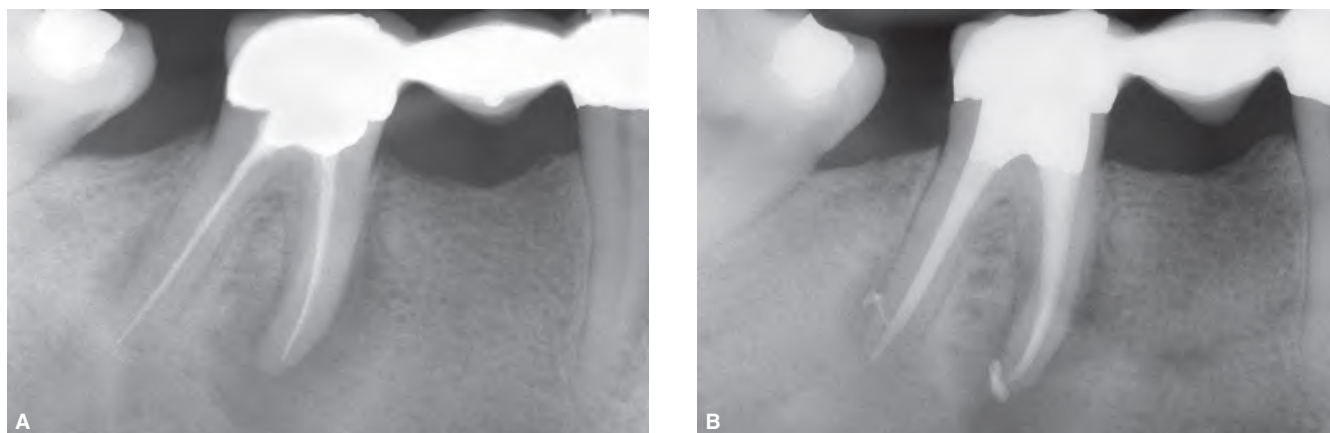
A. Preoperative radiograph showing an endodontic failure in a mandibular molar serving as a posterior bridge abutment. Note, the amalgam in the pulp chamber and that the mesial root appears to have been ledged. B. Post-treatment radiograph showing ledge management with the obturation materials following the root curvature.
